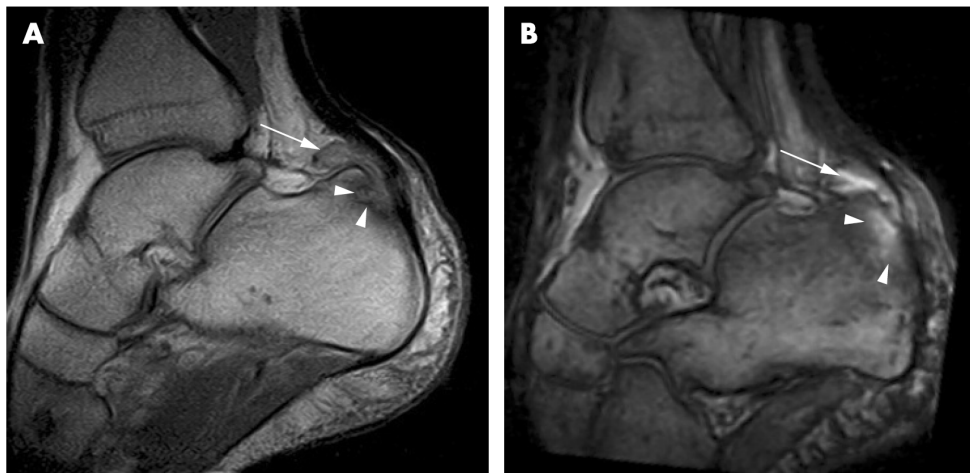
Achilles tendon enthesitis of an 18-year-old man diagnosed with juvenile spondyloarthritis. (A) MRI image without contrast agent (B) MRI image with contrast agent [7] coming from [23].
